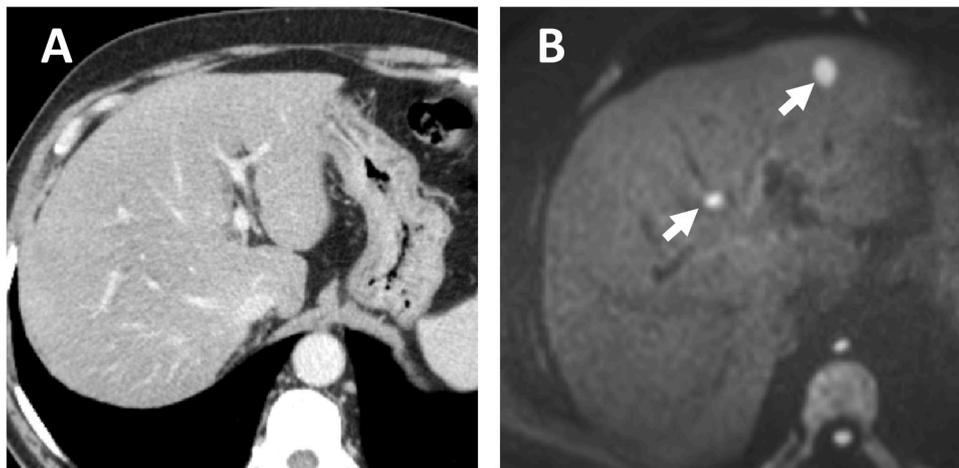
Importance of MRI for hepatic staging. In a contrast-enhanced CT for PDAC staging (A), no liver lesions were found. The staging MRI clearly revealed hepatic metastases (arrows) with restricted diffusion on DWI (B).
